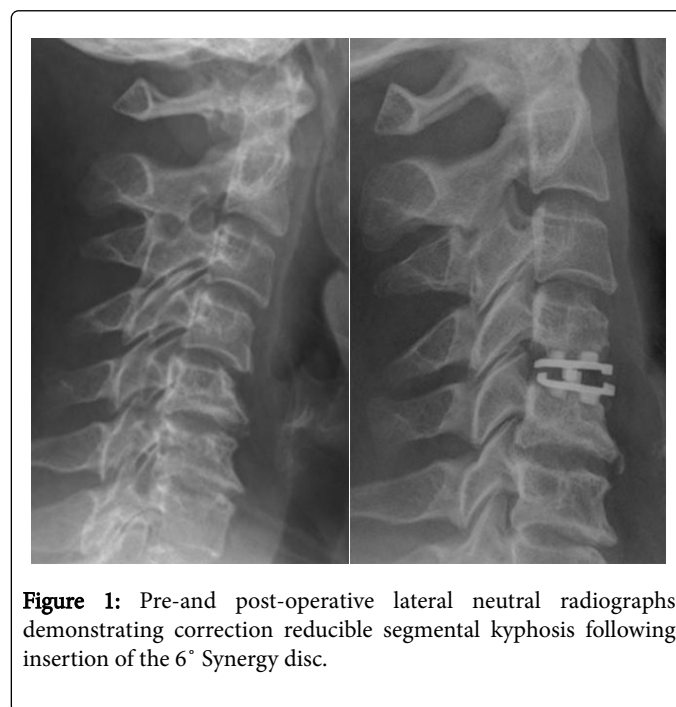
Pre-and post-operative lateral neutral radiographs demonstrating correction reducible segmental kyphosis following insertion of the 6° Synergy disc.
